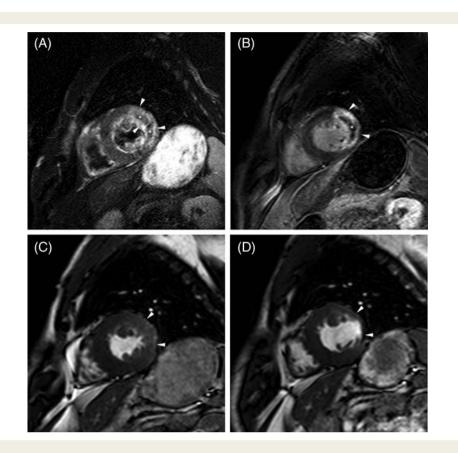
Extensive lateral haemorrhagic infarction in a 48-year-old man. Short-axis T2-weighted magnetic resonance imaging (A), contrast-enhanced magnetic resonance imaging at 1 week (B), and cine magnetic resonance imaging (end-systolic time frame) at 1 week (C) and at 4 months (D). T2-weighted magnetic resonance imaging (A) shows the area of increased signal intensity in the left ventricular lateral wall (arrowheads), and the presence of a large hypointense core (asterisk) corresponding to an area of myocardial haemorrhage. Contrast-enhanced magnetic resonance imaging at 1 week (B) shows complete transmural enhancement of the left ventricular lateral wall (arrowheads) with central area of microvascular obstruction (asterisk). On cine magnetic resonance imaging (C and D), important thinning of the left ventricular lateral wall between baseline and 4 months can be well appreciated. Important impact on left ventricular ejection fraction (30% at 1 week) without functional recovery at 4 months (31%), and obvious increase in left ventricular end-systolic volume, 116 mL at 1 week to 157 mL at 4 months.
